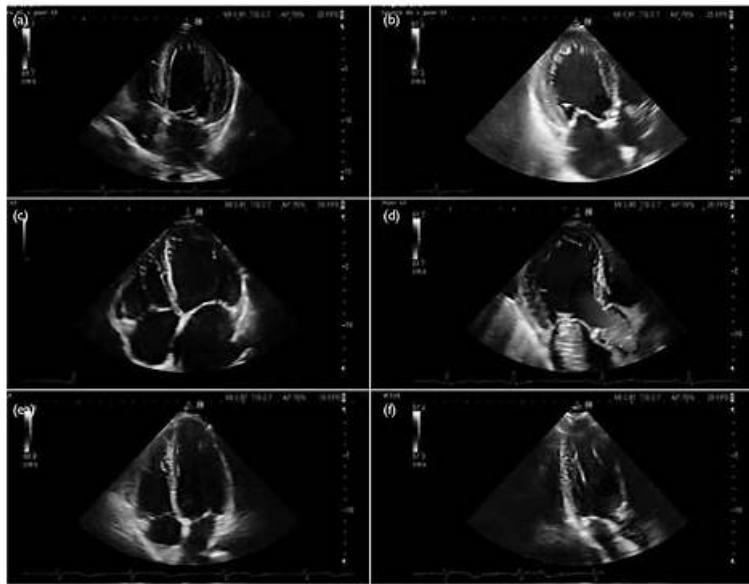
(a, c, e) Apical 4-chamber views and (b, d, f) apical 3-chamber views captured by transthoracic echocardiography. (a, b) Images of a 77-year-old patient with severe aortic stenosis, dilated left ventricle, and left ventricular hypertrophy. The heavy calcification on the aortic valve can be appreciated on the apical 3-chamber image. (c, d) Images of a 70-year-old patient with severe functional mitral regurgitation and heart failure with reduced ejection fraction (left ventricular ejection fraction 29%). The mitral regurgitant jet can be appreciated on colour Doppler imaging in the apical 3-chamber image while both images show dilated left ventricle and left atrium. This patient suffered from moderate-to-severe tricuspid regurgitation as well, with dilated right ventricle and right atrium. (e, f) Images of a 34-year-old healthy individual.
